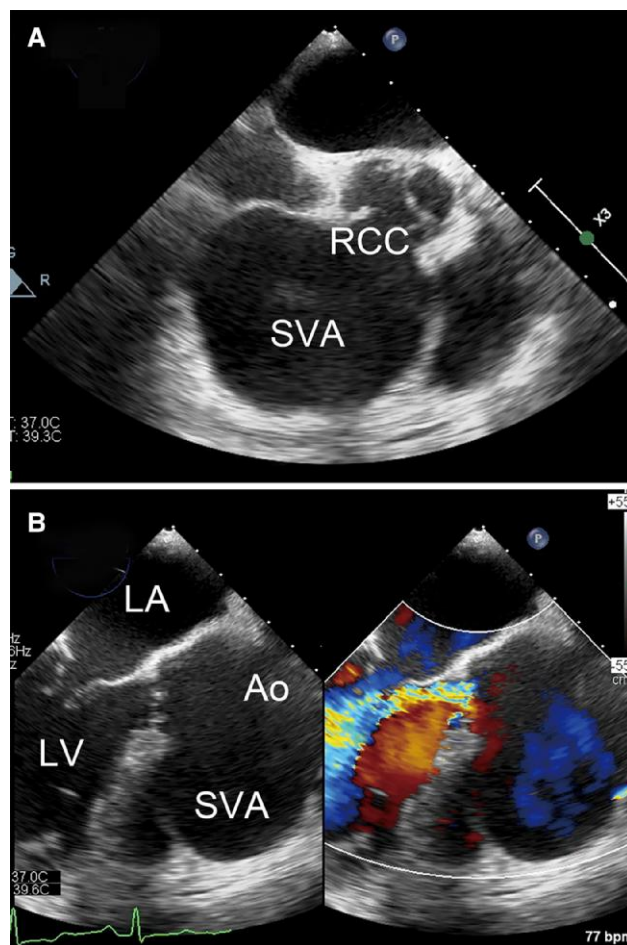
Transoesophageal echocardiography findings. (A) Short axis imaging: large right sinus of Valsalva aneurysm. (B) Long axis imaging: grade II/IV aortic valve regurgitation with severely dilated right coronary cusp. Ao, ascending aorta; LA, left atrium; LV, left ventricle; RCC, right coronary cusp; RV, right ventricle; SVA, sinus of Valsalva aneurysm.
